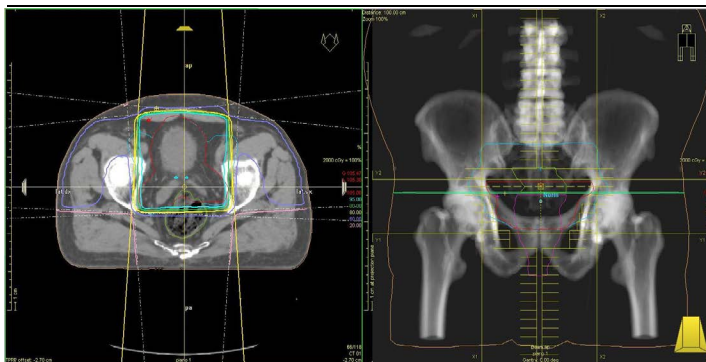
A digitally reconstructed radiographs, and dosimetric study of bladder irradiation.
